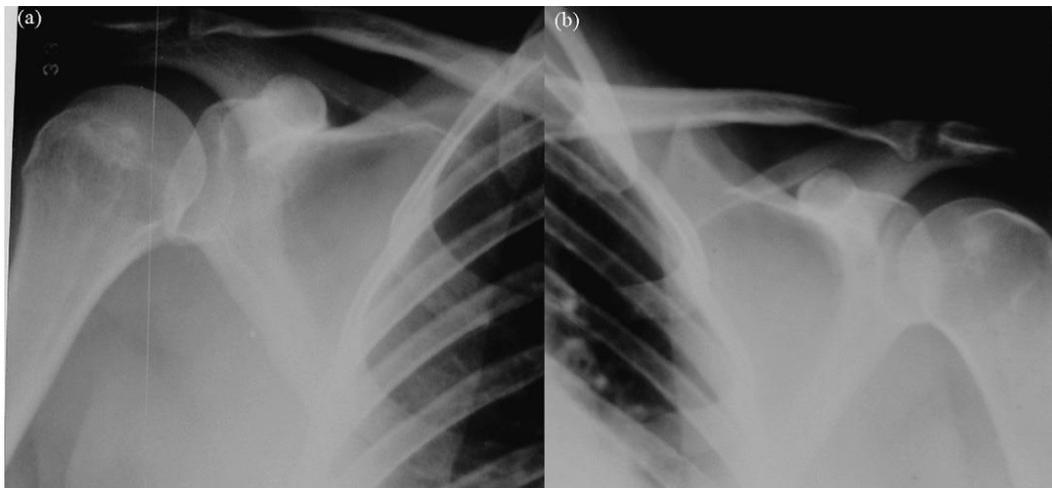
X-Rays after the reduction of both dislocations
